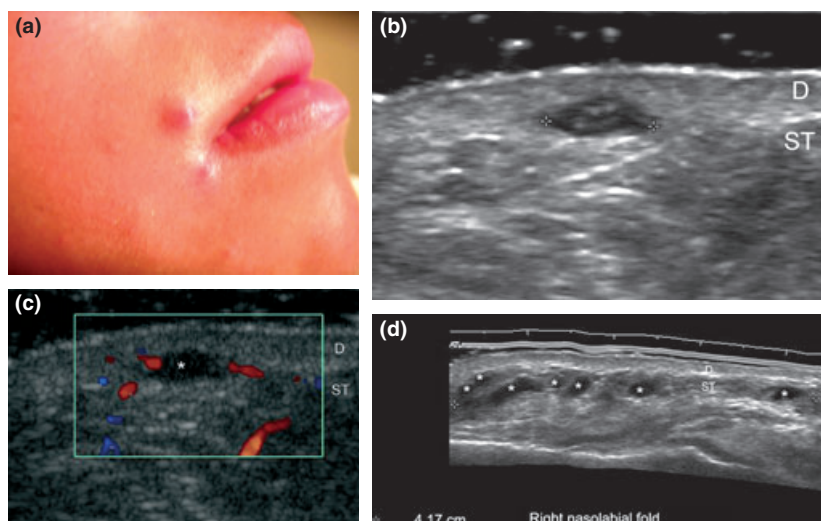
Hyaluronic acid dermatopathy. (a) Swelling and erythema in the right nasolabial fold. (b) Ultrasound (transverse view) showing anechoic epidermal cyst at the dermis/subcutaneous border (between markers). (c) Colour Doppler ultrasound (transverse view): increased blood flow surrounds the cystic structure. (d) Ultrasound (panoramic longitudinal view) of the right nasolabial fold shows multiple anechoic pseudocysts in the subcutaneous tissue corresponding to hyaluronic acid deposits (*). D, dermis; ST, subcutaneous tissue.
